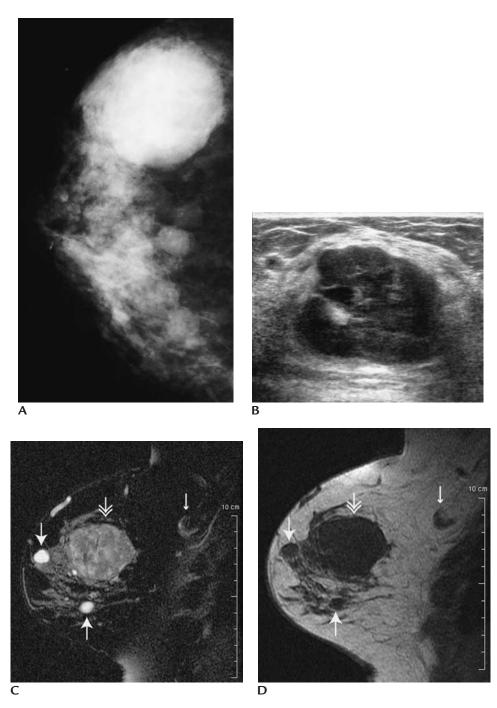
Phyllodes tumor, malignant with liposarcomatous changes. (A) Round dense mass laterally in the right breast new compared with prior mammogram 8 months previously. Additional smaller masses are present consistent with multiple cysts (ultrasound of cysts not shown). (B) Round mass with heterogeneous echotexture, circumscribed, lobulated margins and posterior acoustic enhancement corresponding to palpable and mammographic finding. (C) Magnetic resonance imaging. Sagittal T2-weighted image with fat suppression. Round mass (*double headed arrow*) with mixed signal intensity corresponding to dominant mass. Two masses (*arrows*) with bright signal consistent with cysts. Low axillary lymph node (*thin arrow*) with central fatty hilar region. (D) Sagittal T1-weighted image. Round mass with low signal intensity (*double headed arrow*). Cysts (*arrows*) demonstrate low signal intensity. Lymph node (*thin arrow*) characterized by high signal intensity from central fatty hilar region.
